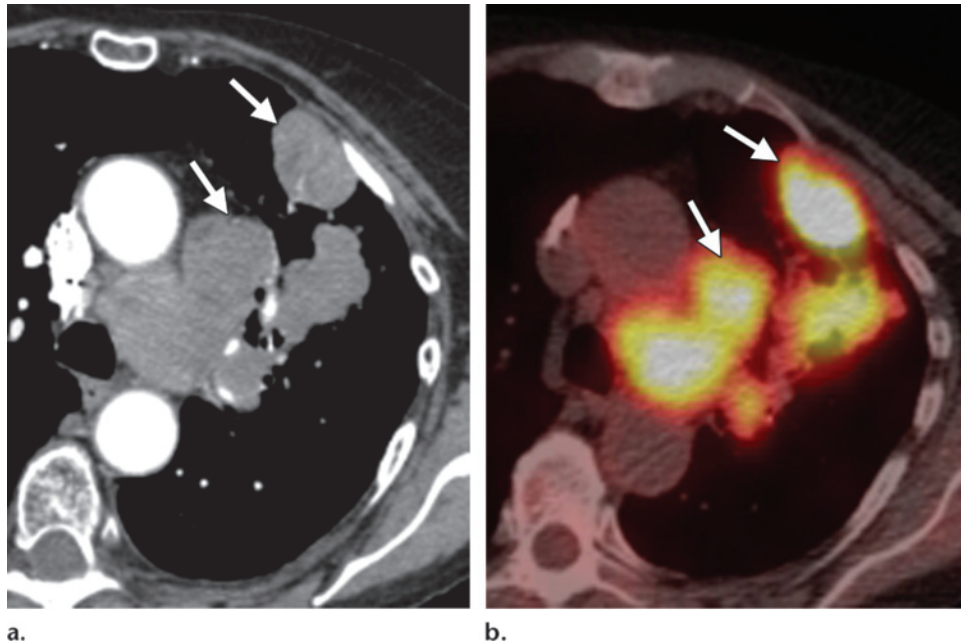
Small cell lung cancer. Chest CT scan (a) and corresponding PET/CT image (b) show a mass in the left lung (top arrow) with intense radiotracer uptake on the PET/CT image. The mass proved to be small cell lung cancer at pathologic analysis. Note the confluent ipsilateral prevascular (bottom arrow) and left paratracheal lymphadenopathy (N2), which shows intense uptake as well. The 7th edition of the TNM staging system can also be used for staging small cell lung cancer.
